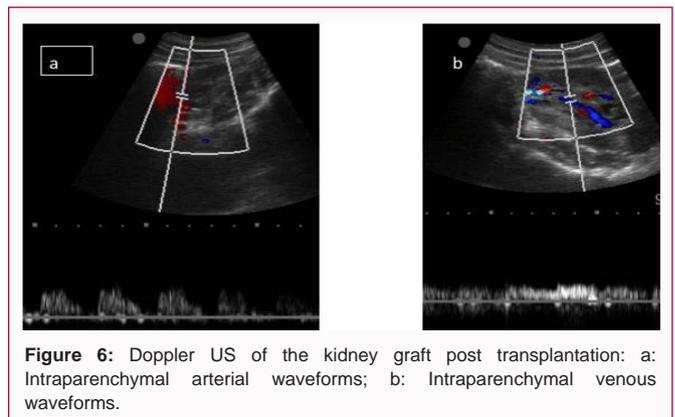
Doppler US of the kidney graft post transplantation: a: Intraparenchymal arterial waveforms; b: Intraparenchymal venous waveforms.
